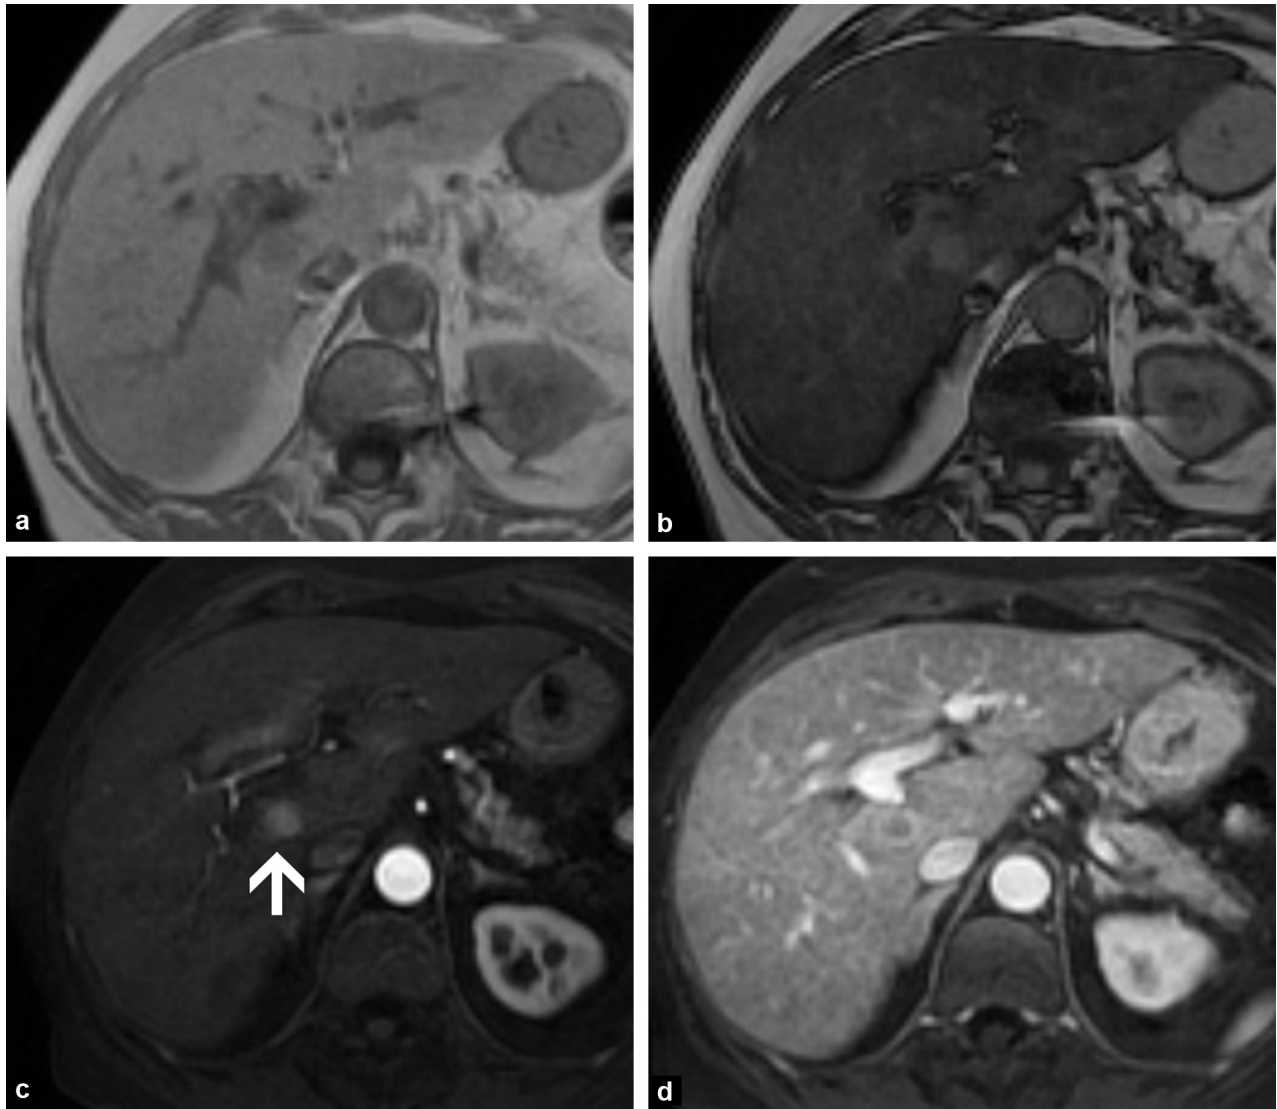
Typical MRI appearance of hepatocellular carcinoma. Monitoring examination for cirrhosis of exogenous origin. T1-weighted MRI in phase (a) and out of phase (b): hepatic steatosis [out-of-phase fall in signal (b)]. T1-weighting with fat saturation after gadolinium injection in the arterial (c) and portal (d) phases: 16 mm lesion (arrow) enhanced in the arterial phase and washed out in the portal phase.
